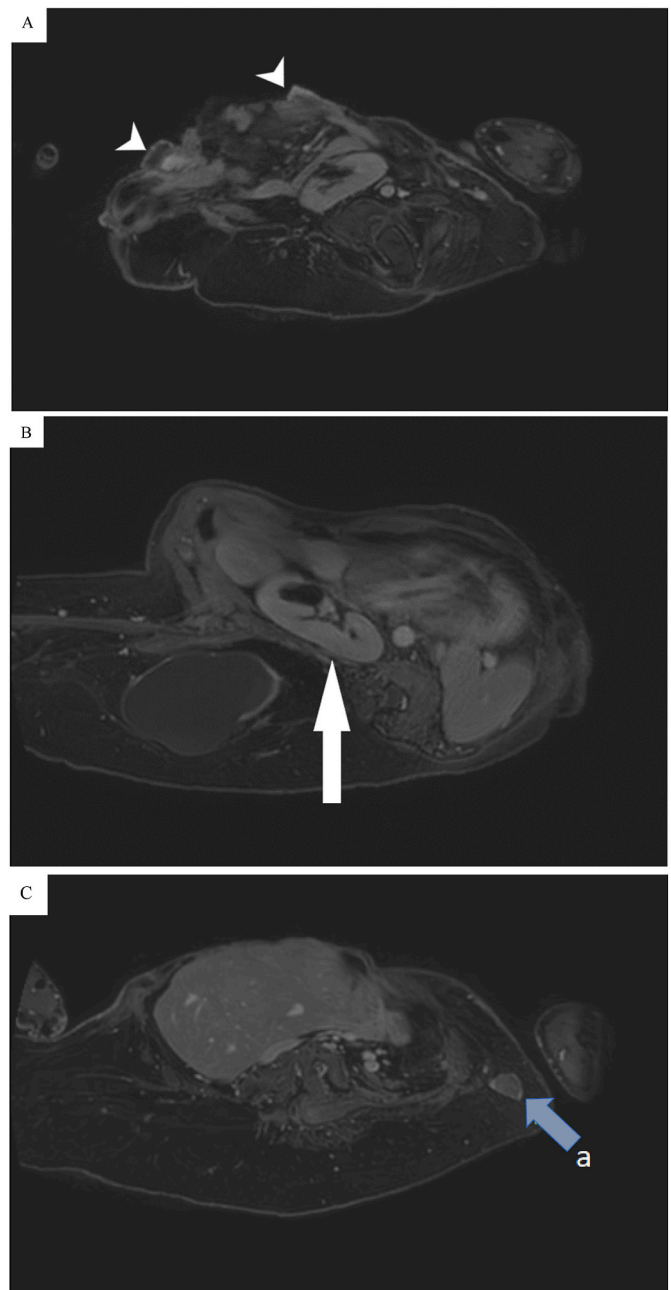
T1 Magnetic Resonance Imaging without contrast, axial view. (A) Left pelvic kidney. Note the kidney is malrotated and posterior to the exposed hemi-bladders, making future percutaneous access unsafe (arrowheads). (B) Right bifid kidney malrotated in transverse lie, also in a location for unsafe percutaneous access (arrow). Note the large lumbosacral myelomeningocele. (C) Possible left testis in the soft tissue posterosuperior to the LLQ colostomy (arrow). Note the minimal margin of soft tissue overlying the liver.
